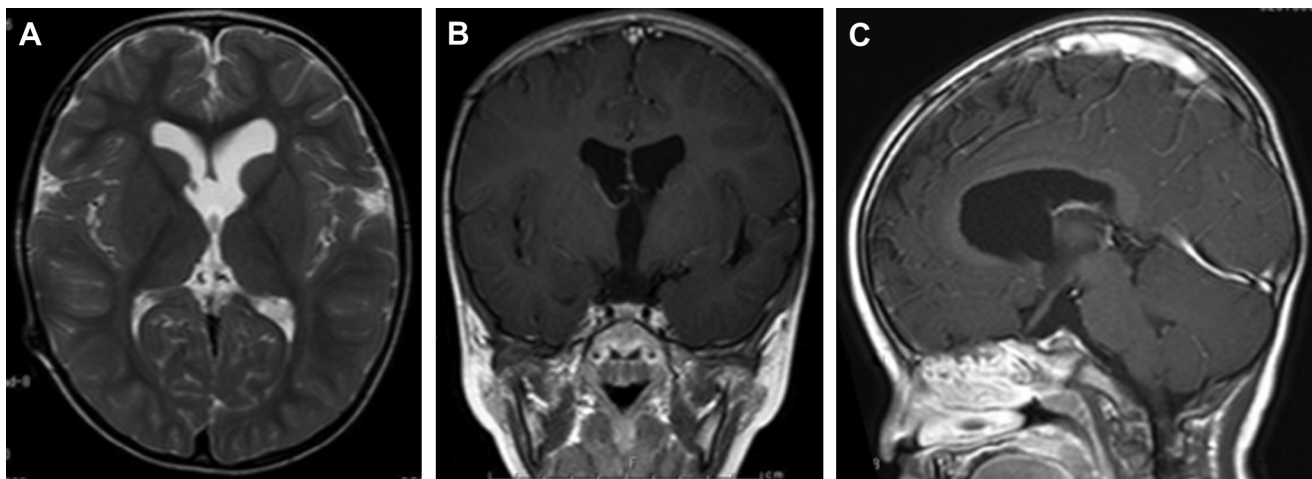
Postoperative magnetic resonance images. (A) T2-weighted image. (B) Coronal contrast-enhanced image. (C) Sagittal contrast-enhanced image.
